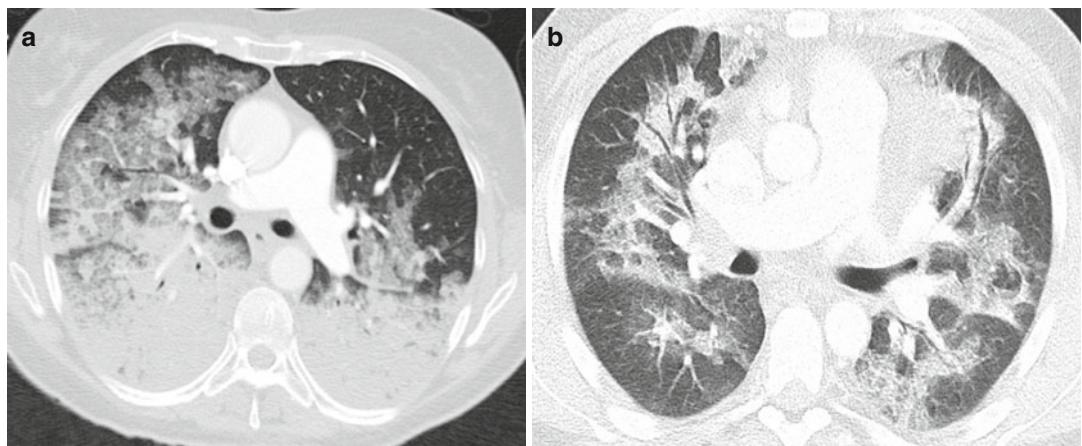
CT pattern of pulmonary edema is very variable and ranges from (a) diffuse ground-glass opacities or consolidations with a ventrodorsal gradient to (b) a patchy
